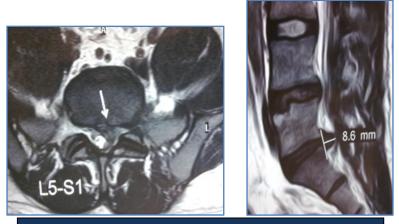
MRI of L-S spine showing IVDP at L5-S1 level
